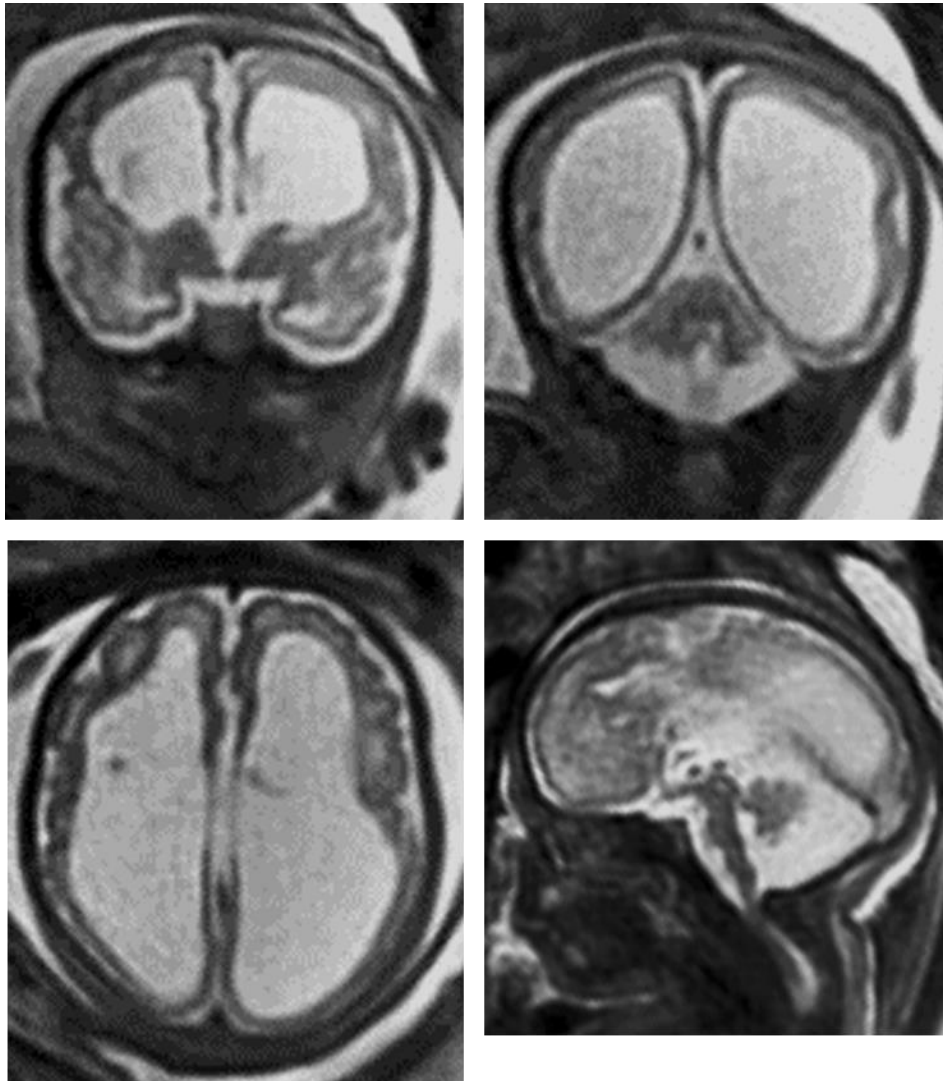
A fetus with pyruvate dehydrogenase deficiency had iuMR imaging performed at 34gw. Coronal (10a and 10b), axial (10c) and sagittal (10d) T2-weighted images show absence of the corpus callosum, severe ventriculomegaly, a thin parenchymal mantle with simplified gyral pattern and cerebellar hypoplasia. The enzyme deficiency was confirmed postnatally.
